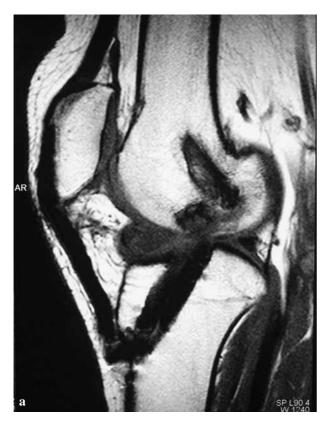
/b. — MRI shows a mass of low intensity signal on T1 and of high intensity signal on T2-weighted sagittal sections located anterior to the ACL graft.
